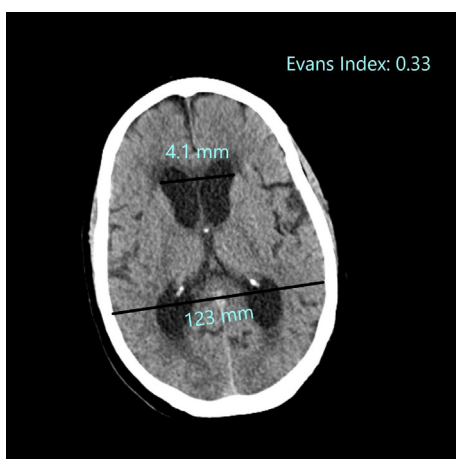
Axial brain CT showing interval enlargement of the ventricular system concerning for normal pressure hydrocephalus. Evans index 0.33.
